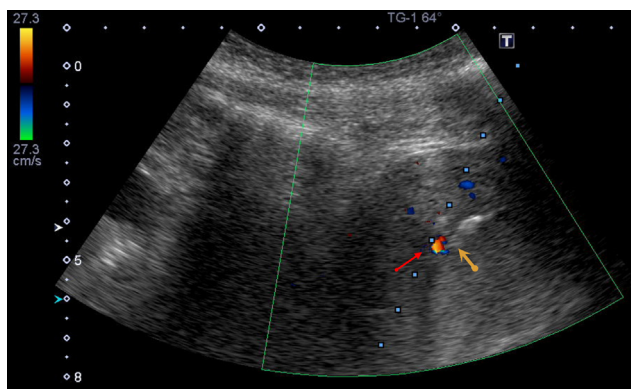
Transabdominal ultrasound image of the uterus with Doppler obtained during embolization shows the tip of the 20-gauge, 89-mm spinal needle (blue arrow) pointing toward the arteriovenous malformation, located in the posterior fundal aspect of the uterus (red arrow).
